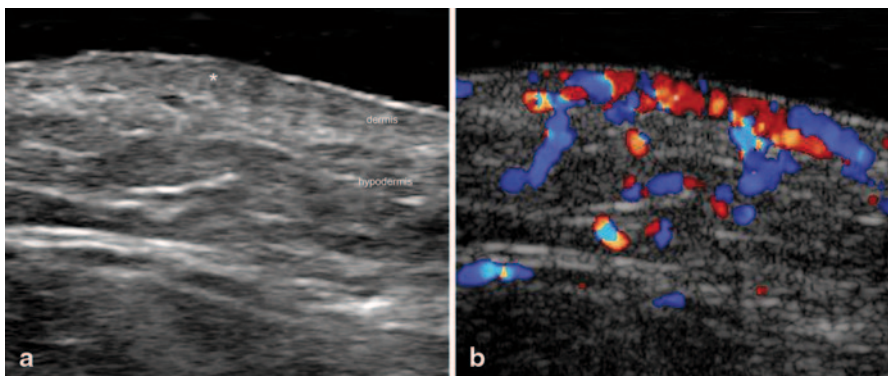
Acute Lupus. a Ultrasound (*gray scale, transverse view, right mandible region*) demonstrates thickening and decreased echogenicity of the dermis in the lesional area (*). b Color Doppler ultrasound shows increased vascularity in the region (*)
